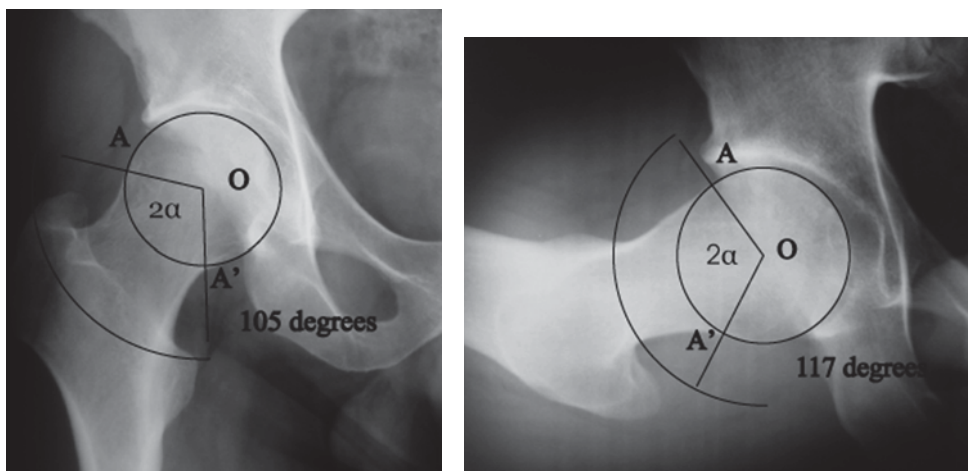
Measuring of the angle 2α in the anteroposterior (left) and DUNN 90 (right) radiographic images of the hips in patients with Cam form of impingement femoroacetabular (explanation of the method is given in the text)
